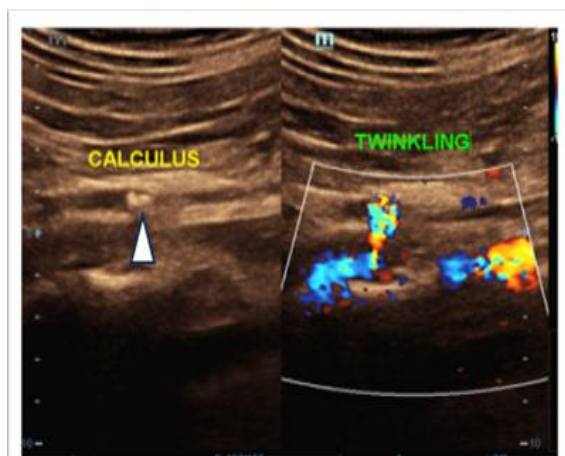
Grayscale and colour Doppler ultrasound of the right mid-ureter. (Left) Grayscale image demonstrates an echogenic ureteric calculus with subtle posterior acoustic shadowing. (B) Colour Doppler image demonstrates a prominent twinkling artefact arising from the calculus, confirming its location within the mid-ureter.
